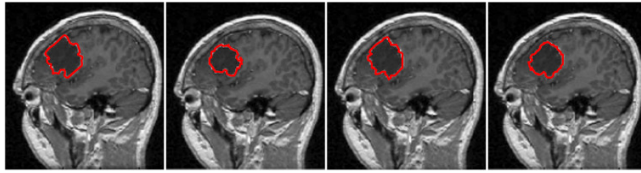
Manual segmentation of glioma on the same MRI performed by four different experts [1]
